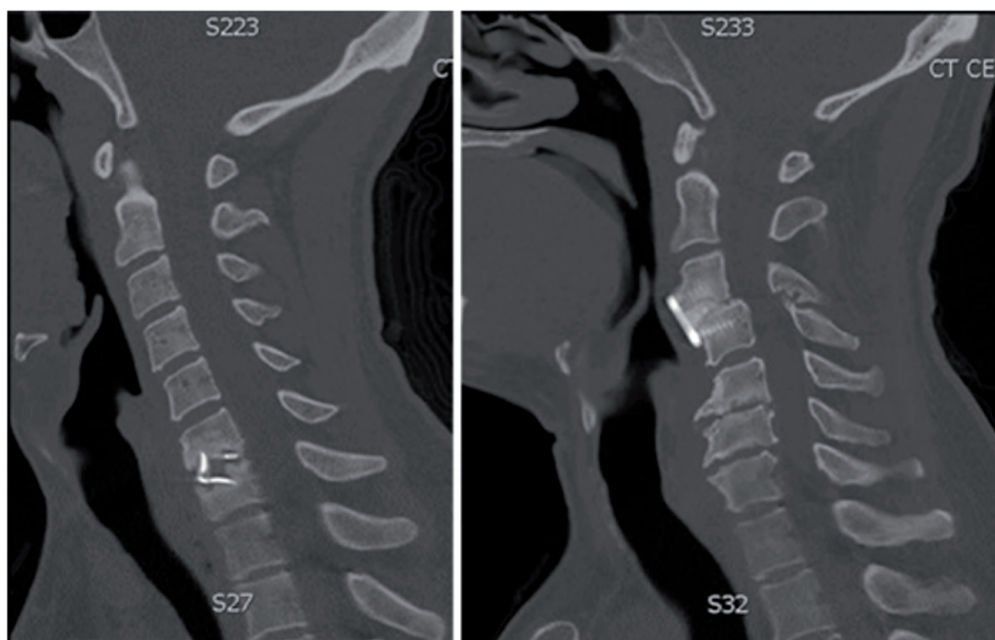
Sagittal X-ray films obtained in a patient with a PEEK interbody graft and pseudarthrosis (left) and a patient with a structural allograft implant (right) healed 1 year after surgery. Reprinted with permission from Krause et al. [58].
